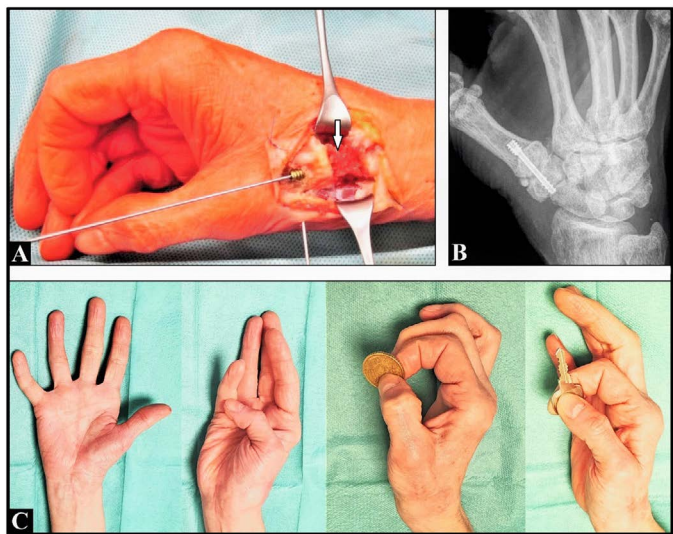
(Case presentation). (A) Intraoperative clinical photograph showing the CMCJ I arthrodesis utilizing a 3,0 mm cannulated titanium headless compression screw and an iliac crest corticocancellous bone graft (arrow). (B) At the 1-year follow-up there was an uneventful bony healing radiographically. (C) Clinical photographs at the 1-year follow-up demonstrating the significant improvement of the thumb function. Note there is no rotation failure of the thumb
